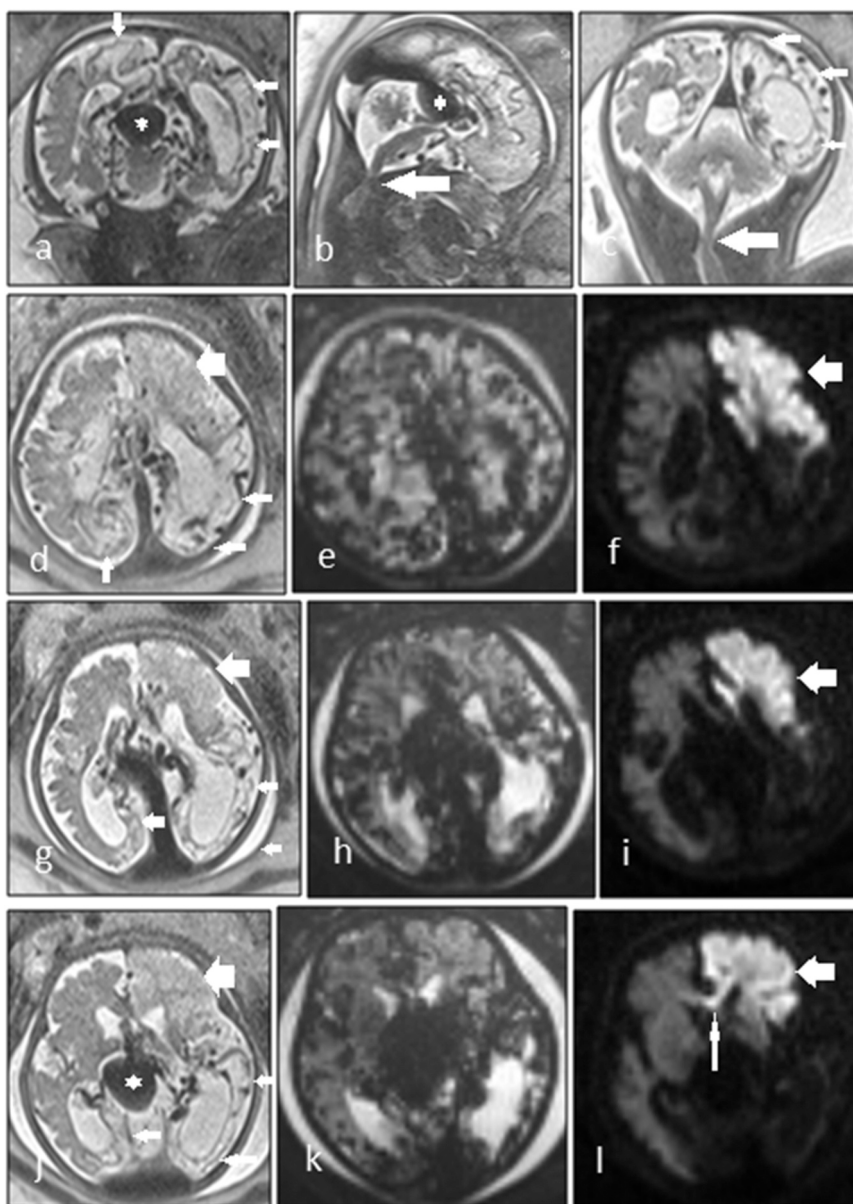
A case of Vein of Galen Malformation (VGAM) with concurrent acute and chronic brain infarct. a,b,c) dilated prosencephalic vein or VGAM (asterisk), straight sinus and dilated tuft of vessels. Extensive encephalomalacia was found bilaterally more prominent in left side (small arrows). d-l) In 3 different axial levels, including T2-weighted images (d,f,g), T2 * -weighted (Hemo) sequence (e,h,k) and DWI sequence (f,i,l) you can see simultaneous acute (large arrows) and chronic (small arrows) fetal brain infarcts and cortical and intraparenchymal hemorrhage. Extension of acute infarct to genu of corpus callosum was present (narrow arrow in l). Foramen magnum stenosis as an accompanying abnormality (large arrows in b,c).
